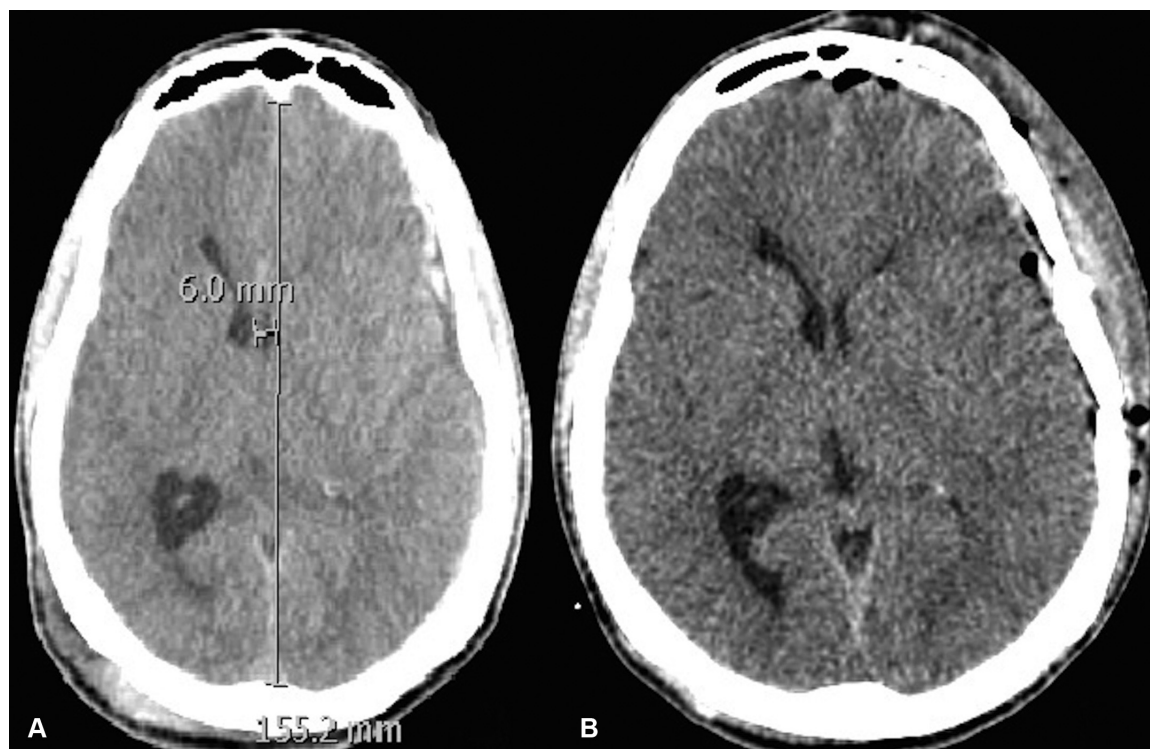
(A) Admission axial brain computed tomography revealing a left subdural hematoma and brain swelling with midline shift; (B) 24-hour postoperative computed tomography revealing swelling reduction and no midline deviation.
